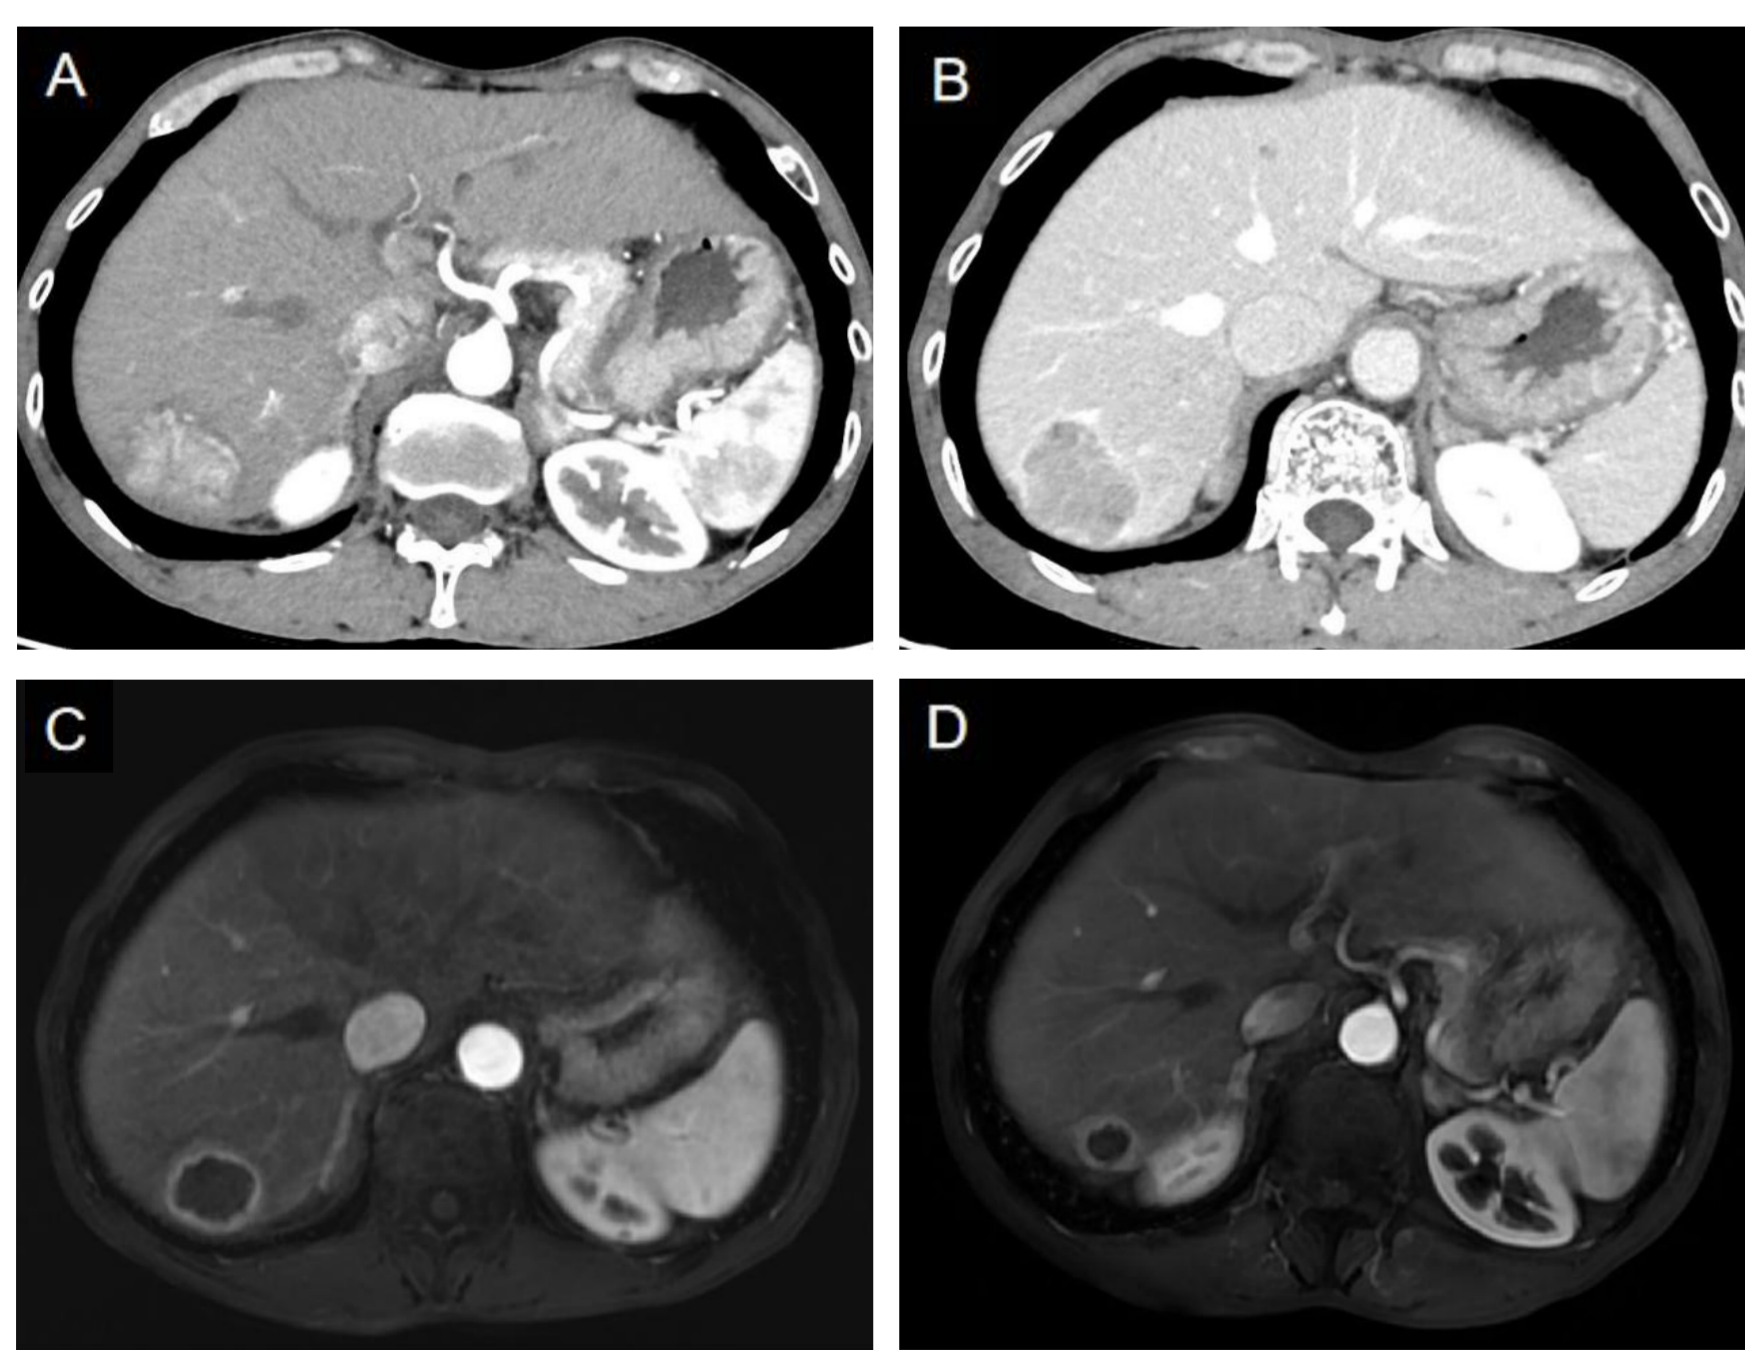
A 66-year-old male with HCC lesion. (A) Contrast-enhanced CT scans of the HCC in the arterial phase. (B) Contrast-enhanced CT scans of the HCC in the portal venous phase. (C) 35 days after A-SIRT (RS), contrast-enhanced MR scans showed shrunken tumor size and necrotic tumor tissues in segment 7 of the liver without enhancement. (D) 6 months after A-SIRT (RS), MR scans showed further shrinkage of the tumor volume.
